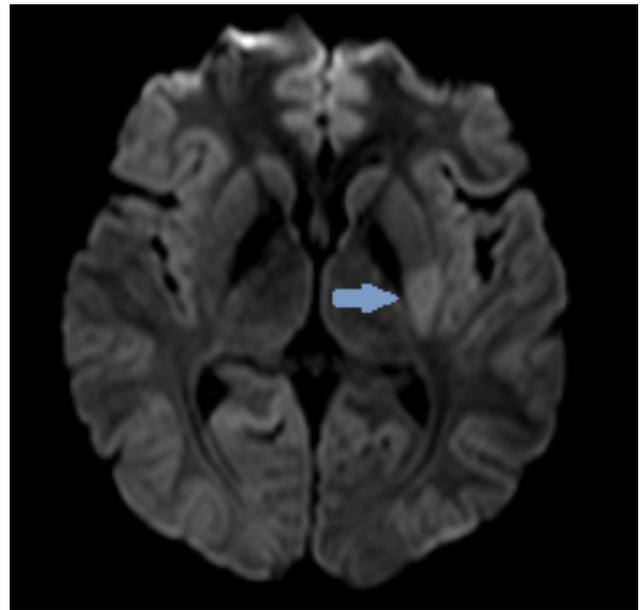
Diffusion MRI shows acute infarction
